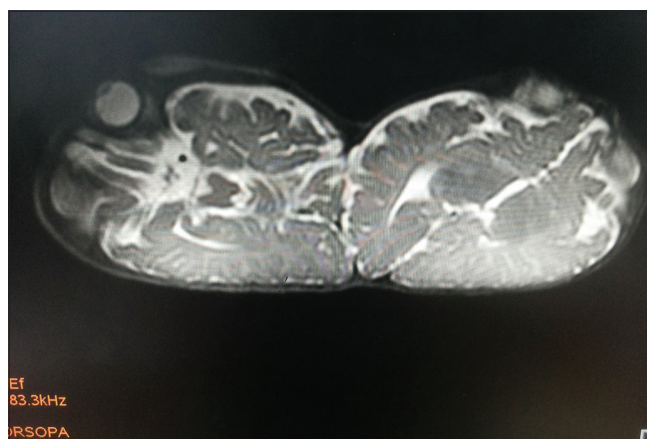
Magnetic resonance imaging of craniopagus twins
